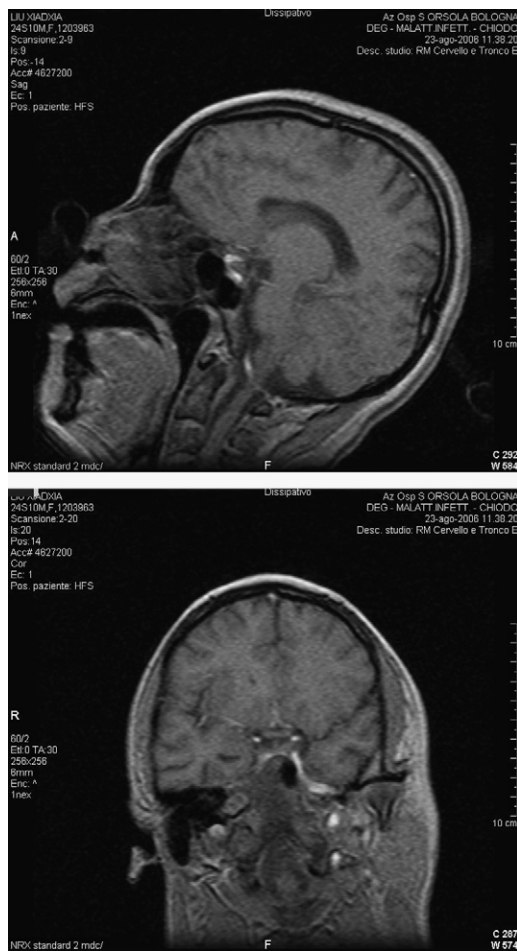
Magnetic resonance imaging (MRI) of the brain of our patient who developed multiple CNS localizations of a neurological and pulmonary tubercular infection, concurrent with a meningeal cryptococcosis. Numerous leptomeningeal lesions in temporal, frontal, pontocerebellar, and hypothalamic sites are interpreted as infectious-inflammatory localizations on gadolinium-enhanced MRI, which also shows the involvement of base and fourth ventricle cisterns, periventricular sites, and associated cranial nerve nuclei.
